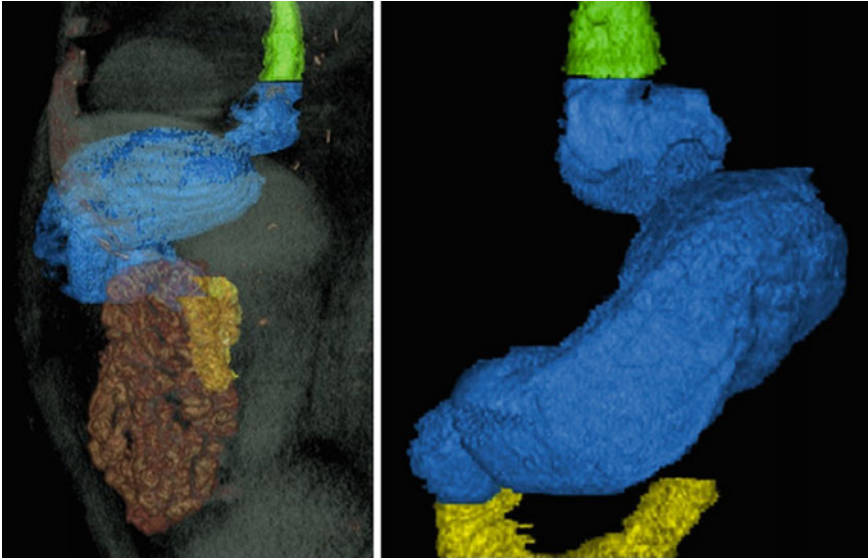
3D computed tomography images showing a recurrent hiatal hernia
